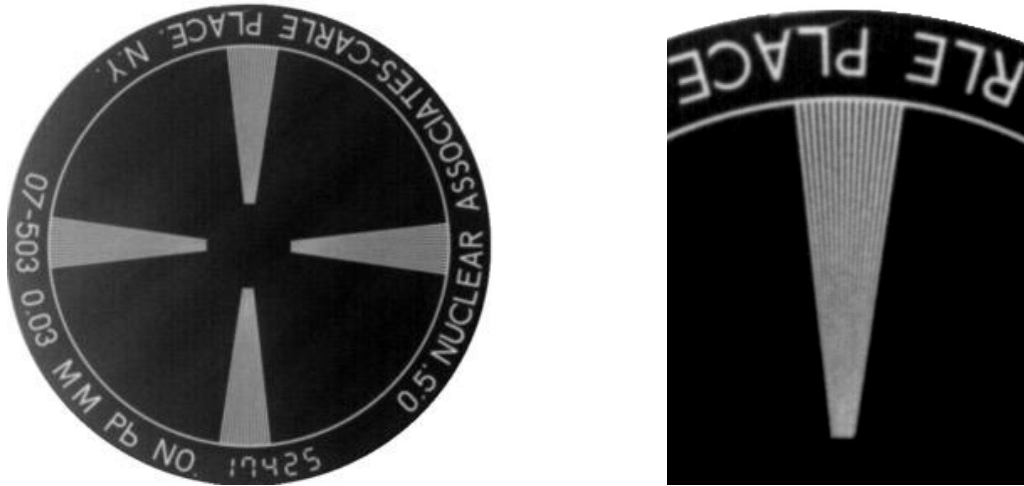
X-ray star pattern of a typical individual source element. Spot size is 0.3 mm x 0.3 mm for $V_{grid} = -300$ V at 45 kV and 50 mA. Magnification on detector = 1.8X.
